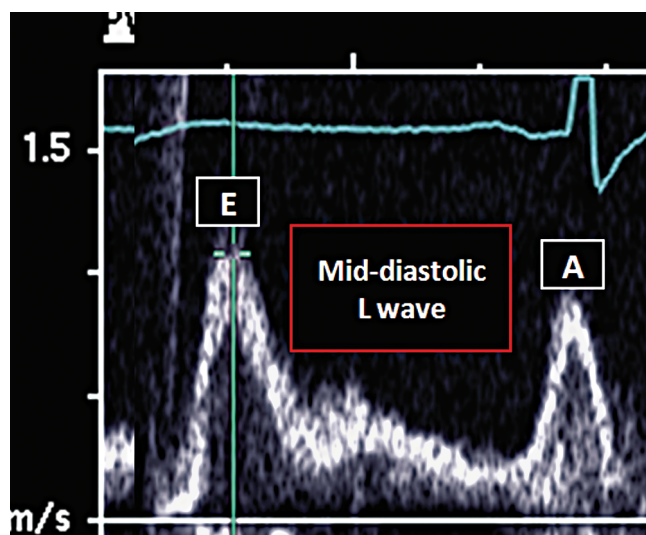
Mid-diastolic wave. Spectral Doppler recordings of the mitral blood inflow reveal abnormal mid-diastolic L wave of an A peak velocity >20 cm/sec, indicative of left ventricular myocardial dysfunction.
